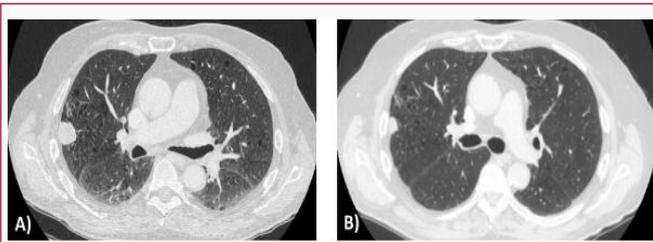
A) Chest computed tomography showing SCLC in upper right lobe, at diagnosis B) and after ten months, without any treatment.
